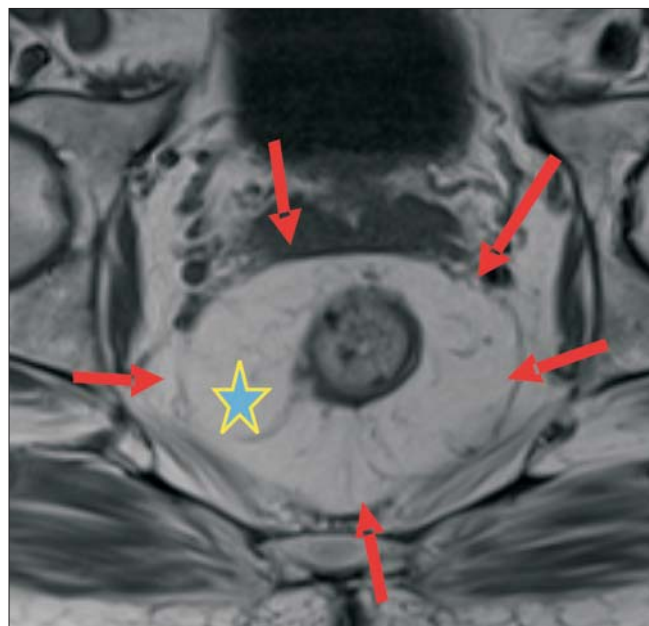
MRI of the rectum. The mesorectum (star) and the mesorectal fascia (MRF) (arrows) are excellently visualized.
